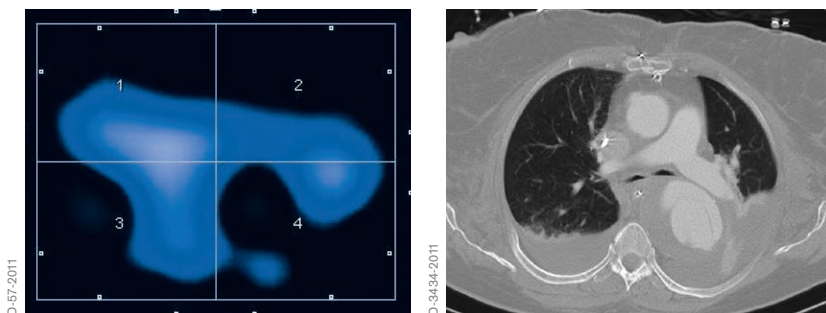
Tidal image and corresponding CT image of a patient with dystelectasis
